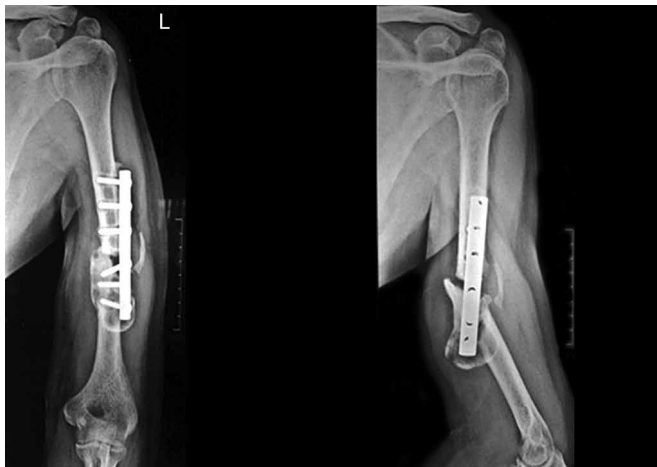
X-ray humerus AP and lateral showing nonunion following inadequate reduction.
